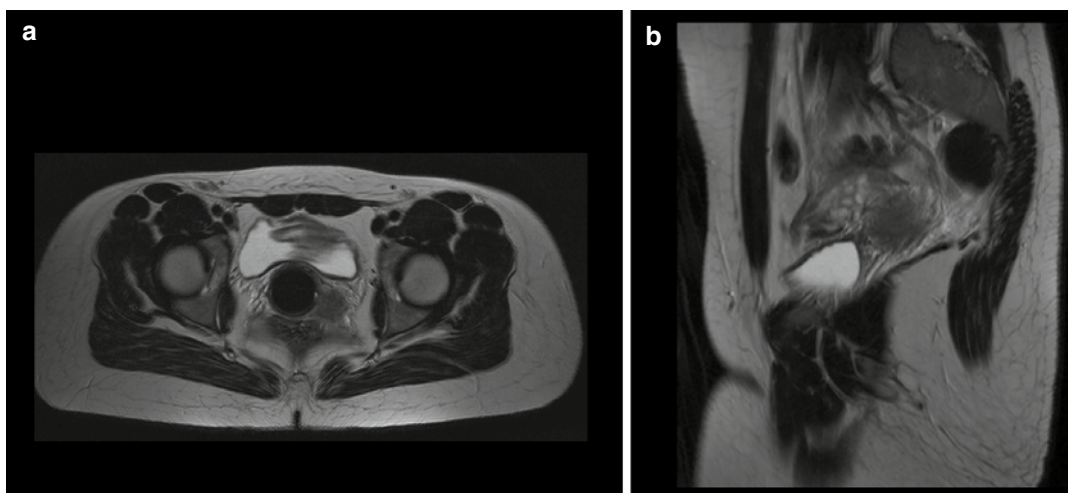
oT3b vaginal carcinoma infiltrating the left mesocolpos and hypogastric subperitoneum. T2-weighted transverse (a) and sagittal (b) MRI scans demonstrate vaginal cancer spreading through the left mesocolpos to the pelvic wall. Here, the tumor is fixed, as assessed by palpation during examination under anesthesia
